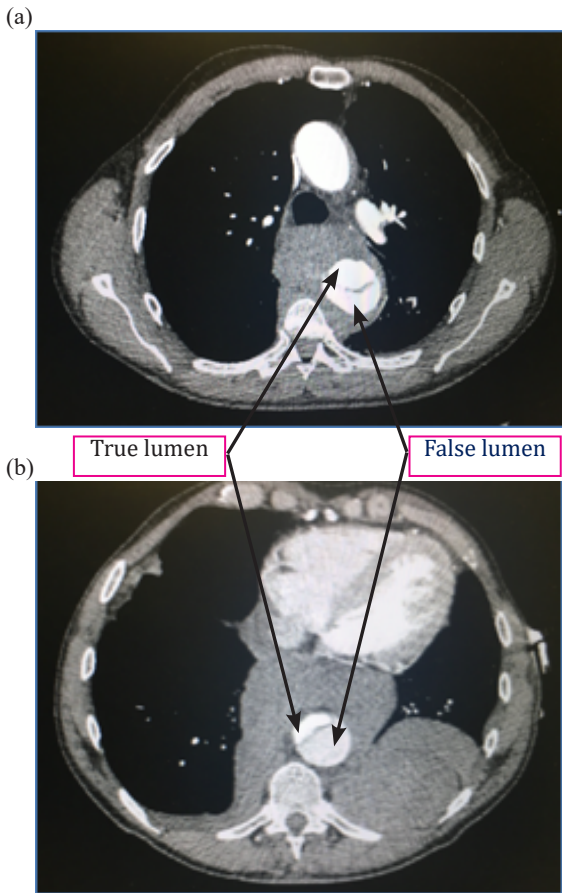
CT angiogram showing a Type B aortic dissection with large mediastinal and pleural haematomas.
